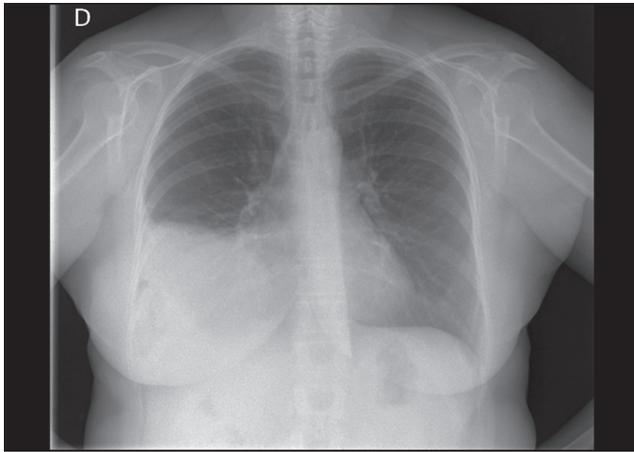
Preoperative Chest X-Rays performed before thoraco-abdominal CT-scan, and showing thoracic lower right opacity with air component.
